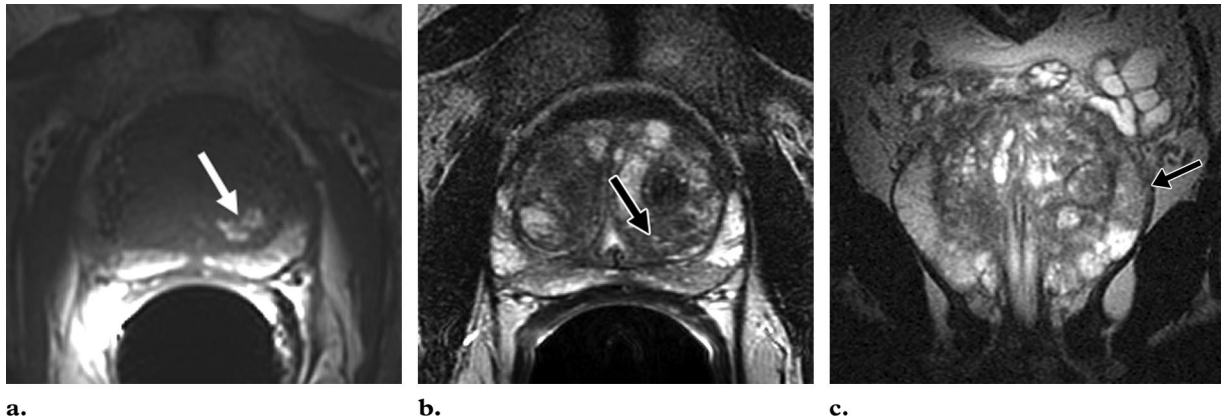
Postbiopsy hemorrhage. T1- (a) and T2- (b) weighted axial MR images and T2-weighted coronal MR image (c) demonstrate extensive bilateral postbiopsy hemorrhage in the peripheral zones. The transition zone in the left lobe demonstrates high signal intensity on the T1-weighted image (arrow in a) and low signal intensity on the T2-weighted images (arrow in b and c).
